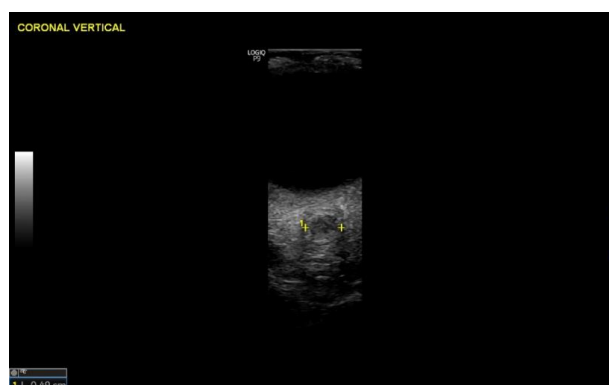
The craniocaudal diameter is measured (anatomically vertical but horizontal on the screen) because the mediolateral diameter might not be perpendicular to the longitudinal axis of the nerve and therefore might appear larger than the actual ONSD. It is not possible to determine the distance between the optic disc and the measured diameter. The best measurement is the largest craniocaudal diameter observed. The Doppler function is not needed. The optical nerve sheath diameter (ONSD) is measured inside the inner borders of the dura mater.
